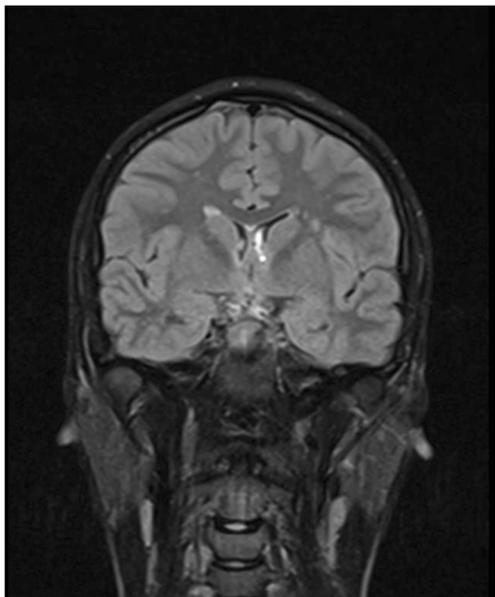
A 15-year-old girl with vit. B12 deficiency. Bilateral parietal periventricular white matter hyperintensities can be seen in the coronal FLAIR image
